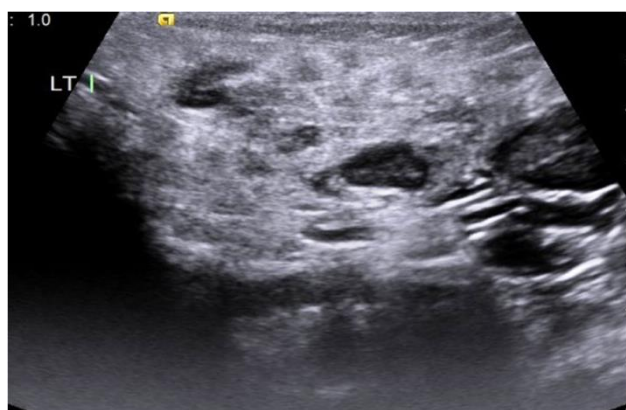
(B): Sonography of parotid gland showing multiple hypoechoic areas.
